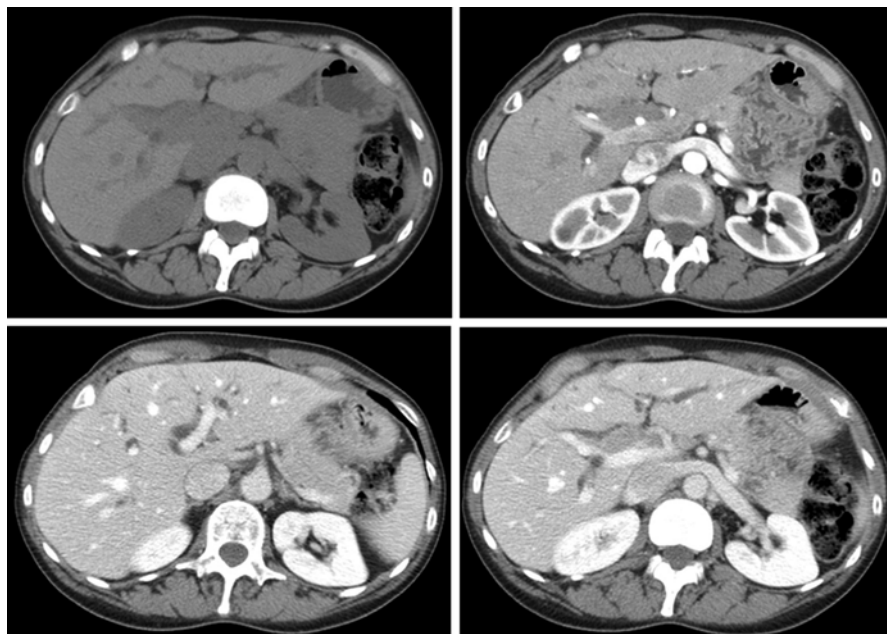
Shown is a CT angiogram of the liver from a 54-year-old woman with abnormal liver enzymes with history of melanoma of the back, upper arm and labia status post definitive resection for all. Physical examination was unremarkable and laboratory examination during surveillance for melanoma yielded a normal total bilirubin, AST=145 U/l, ALT=516 U/l, and ALKP=158 U/l. A PET scan to rule out melanoma was negative for FDG avidity. Fine needle aspiration by referring physician showed a spindle cell neoplasm that was S-100 positive and c-Kit, desmin and synaptophysin negative. At operation, a soft mass was noted arising from the proximal bile duct extending into the base of segment IV. On frozen section, a low grade spindle cell neoplasm consistent with a Schwannoma was noted. Resection of the extrahepatic bile duct ensued and the patient recovered well with normalization of liver enzymes and no further sequelae
